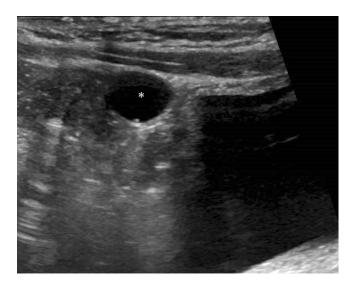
Longitudinal ultrasound image in a neonate demonstrates an anechoic cyst (*asterisk*) just superior to the dome of the bladder consistent with a urachal cyst.
